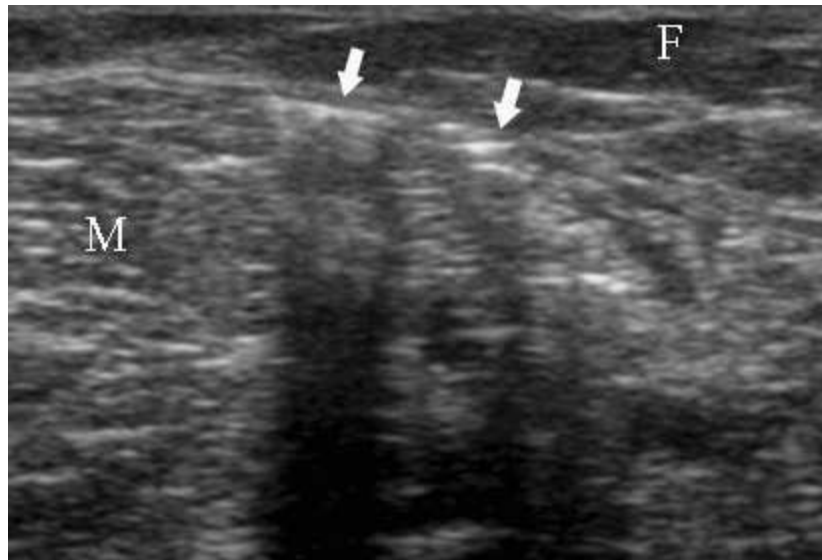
A transverse sonographic image of the arm taken just above the proximal margin of the skin induration and erythema demonstrates a hyperechoic foci (arrows) with posterior acoustic shadowing above the deep fascia corresponding to gas bubbles. At that level of the upper extremity the fatty tissue still appears normal. F - fatty tissue, M - muscles.
